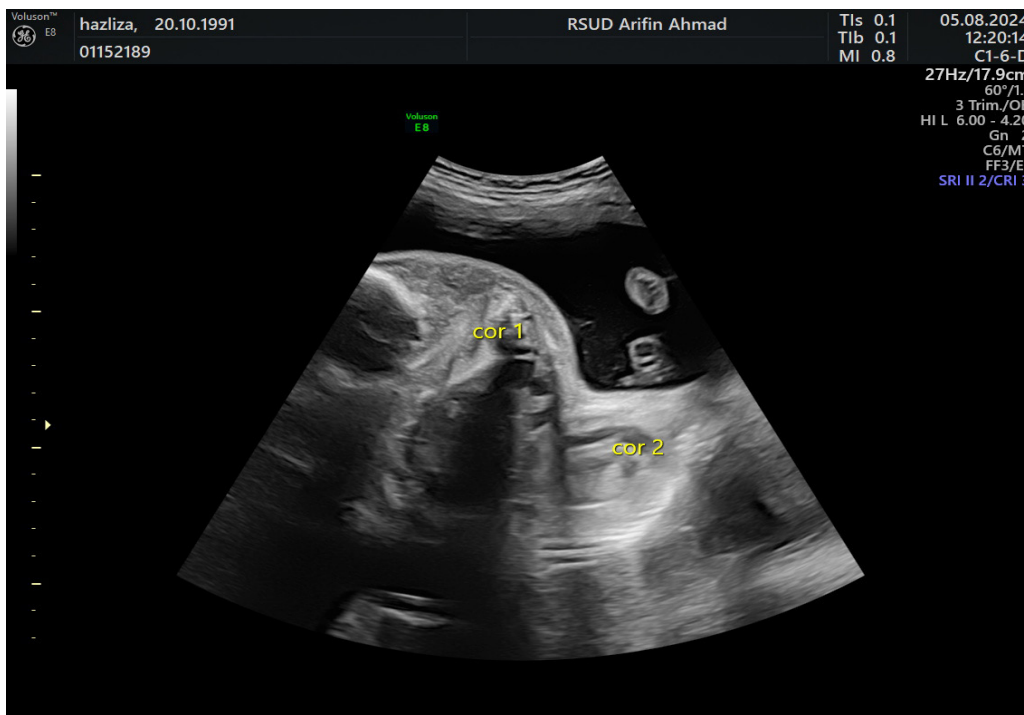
Ultrasound examination of the thorax shows that the fetus appears to be united and the two hearts are close together
